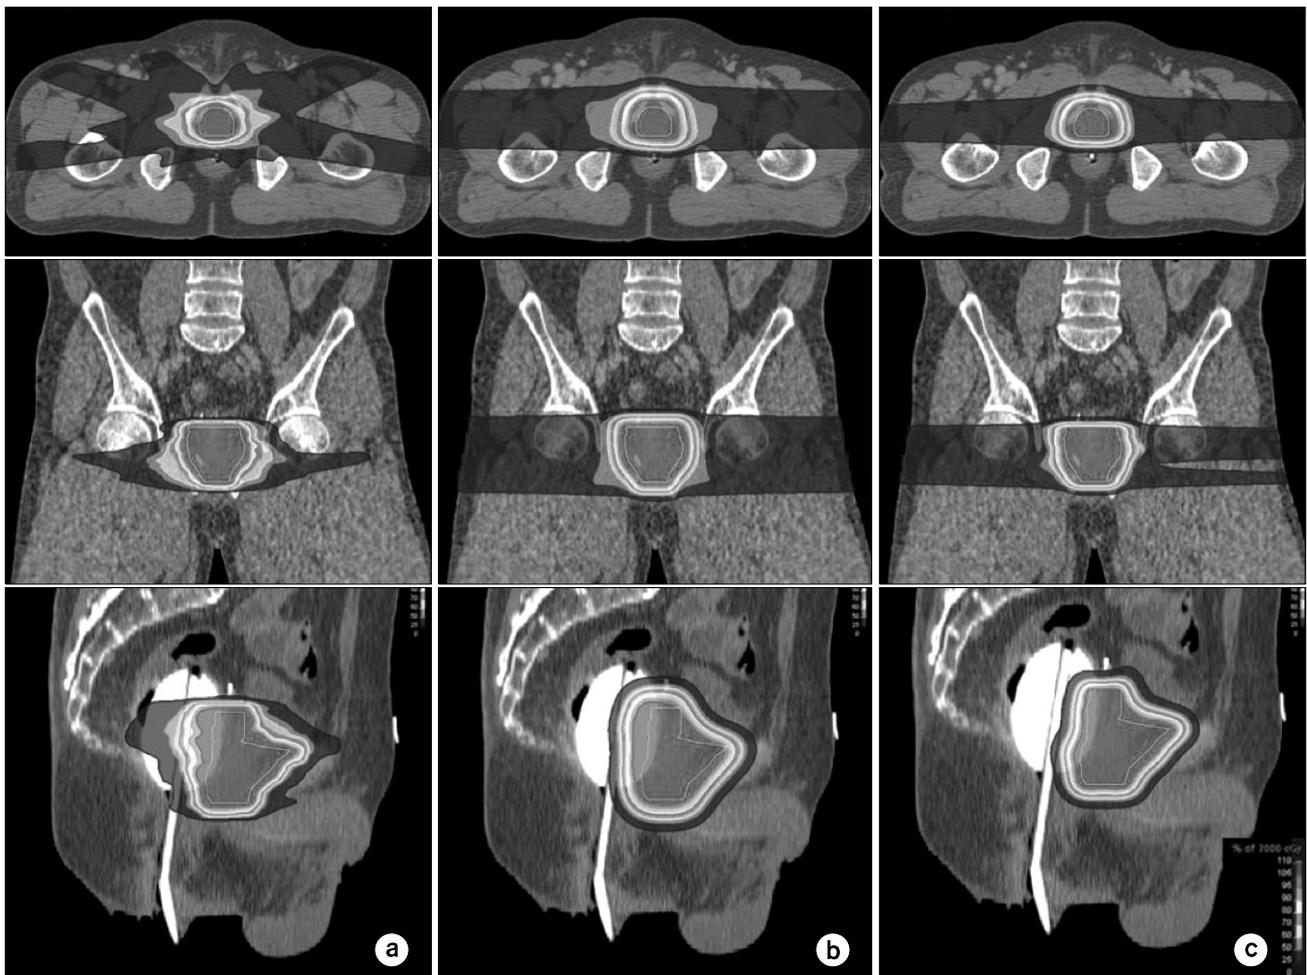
Color wash IMRT (a), USPT (b), and IMPT (c) dose distribution for the PTV for patient (patient 3) with a prostate cancer. It shows the dose distributions of IMRT, USPT, and IMPT plans for CT image on axial, frontal, and sagittal planes, respectively. IMPT and USPT dose distributions delivered by right lateral (270°) and left lateral (90°) beams.
